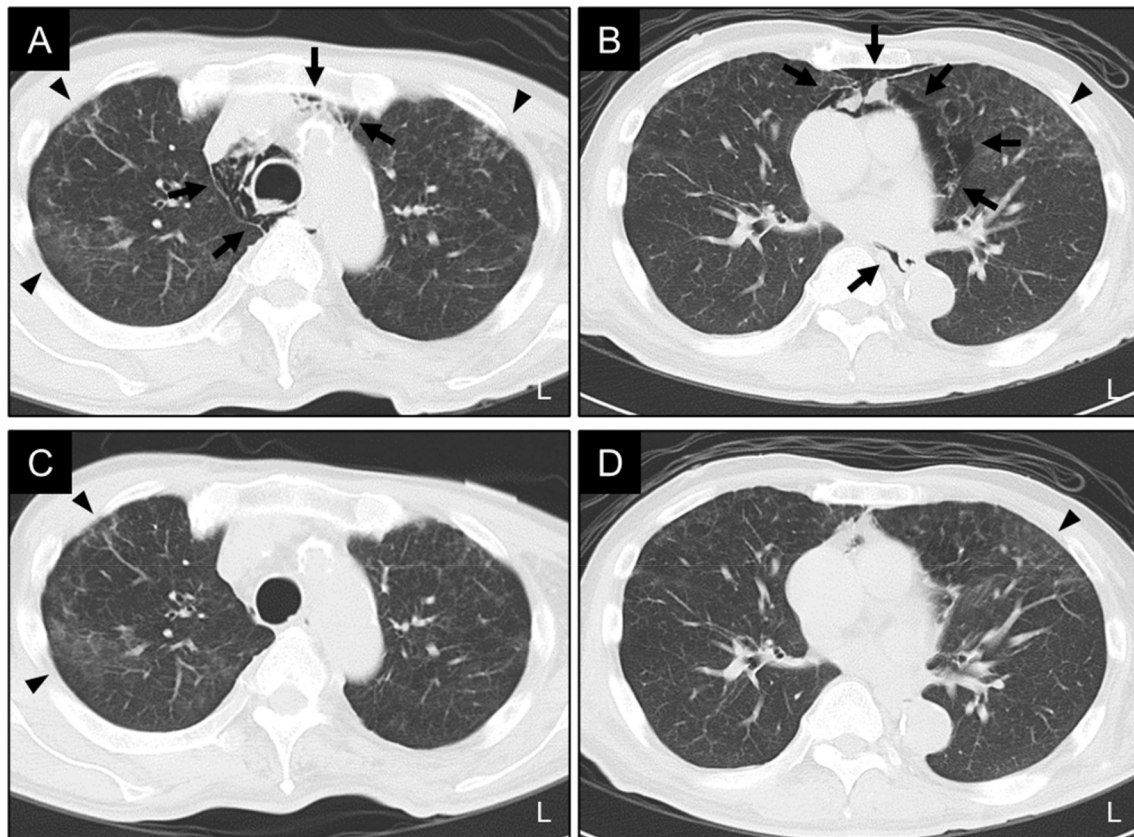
Series of chest computed tomography images of a patient with amyotrophic lateral sclerosis with pneumomediastinum while using mechanical insufflation-exsufflation after recovery from riluzole-induced interstitial lung disease.
